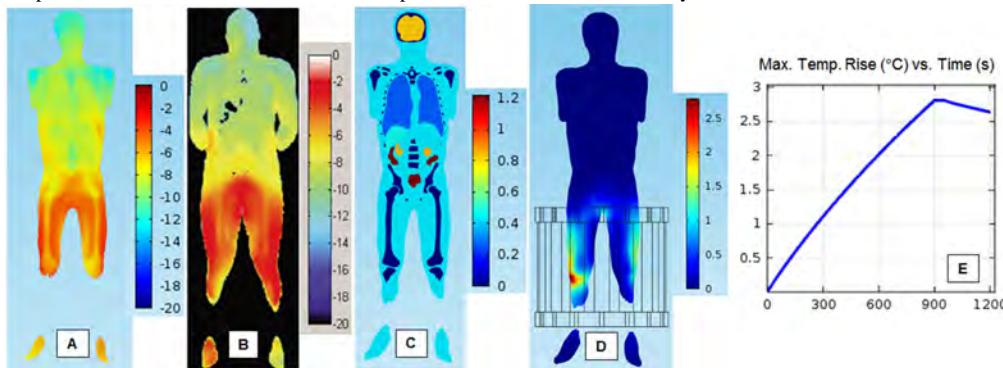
(A & B) Partial body SAR distributions averaged over 10 g spheres, log scale for coronal slice plane from 3T birdcage MRI coil at knee location for (A) current study solution developed using COMSOL Multiphysics[®] FEA and (B) visible Man FDTD solution by Wang 2012⁵. (C) Electrical conductivity (S/m). (D) Temp. rise (°C). (E) Maximum temperature rise (°C) vs. time (s).
